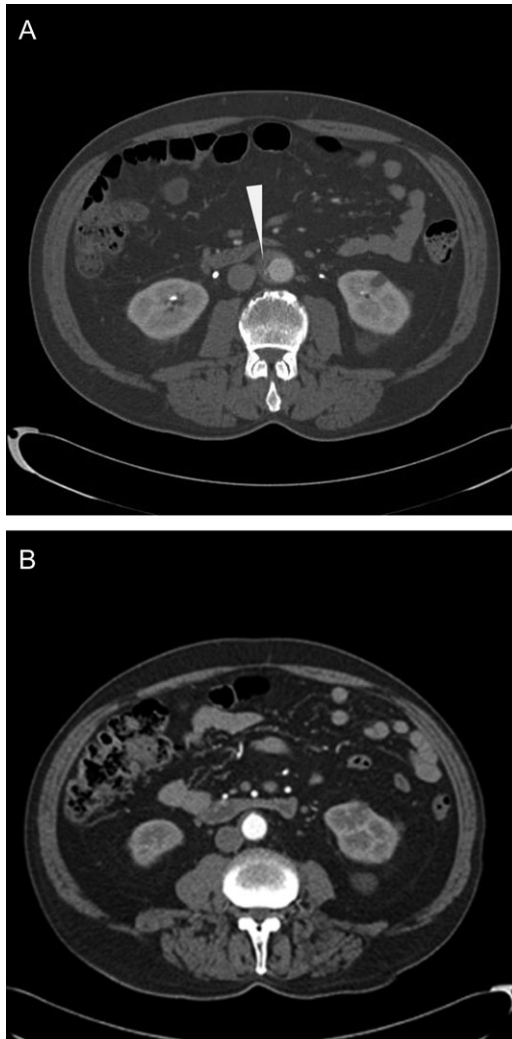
(A) CT scan showing periaortic oedema of the abdominal aorta at diagnosis. (B) CT scan of abdominal aorta at 2 months (inflammation indicated by arrowheads).
